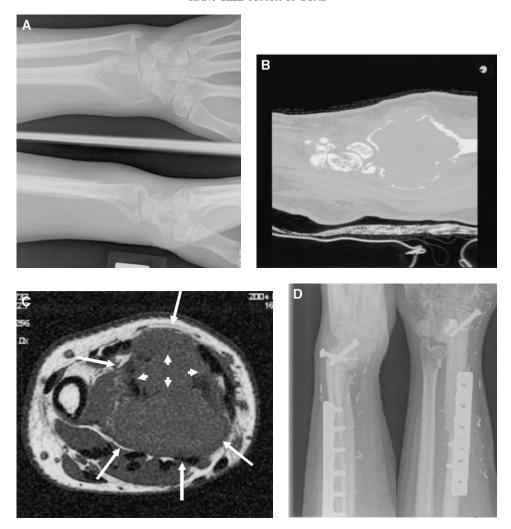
(A) Anteroposterior (top) and lateral (bottom) plain radiographs of a 20-year-old woman with a stage 3 GCT of distal radius. (B) CT scan of sagittal reconstruction showing subchondral bone erosion, deformation, and soft-tissue extension. (C) Axial MRI cut shows remains of the original outline of distal radius (arrowheads) and extensive soft tissue involvement (long arrows). (D) Lateral (left) and anteroposterior (right) radiographs showing results of en bloc resection and reconstruction that used a vascularized fibula to achieve fusion to the proximal carpal row.
